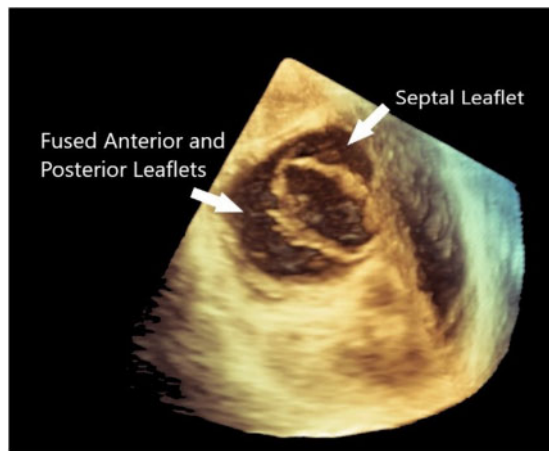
Three-dimensional transoesophageal echocardiography (TOE) showing atrial view of the tricuspid valve (TV) with two leaflets. AP, fused anterior and posterior leaflets; S, septal leaflet.
